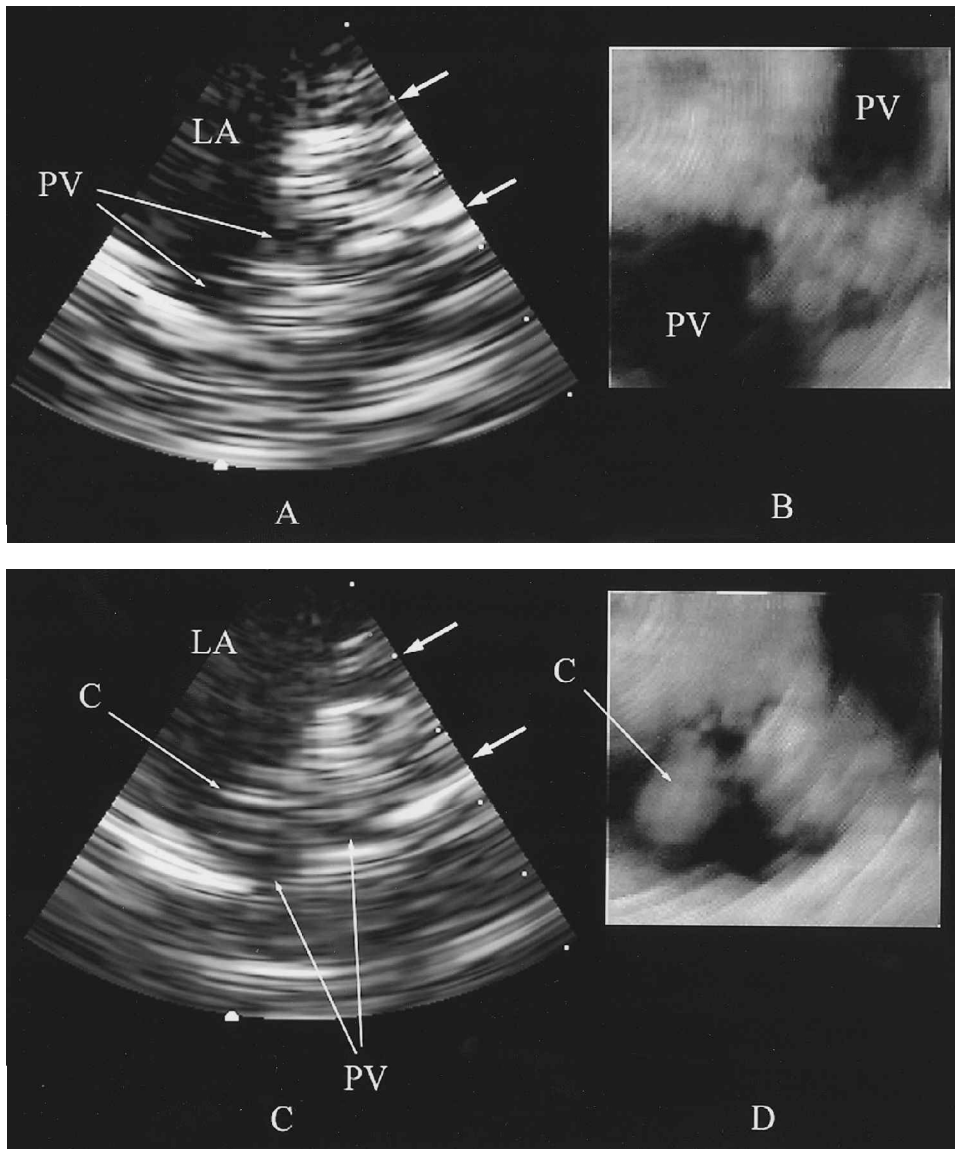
Three-dimensional intracardiac echocardiographic scan with imaging catheter in the left atrium (LA) including (A) a sector image of right pulmonary veins (PVs), (B) simultaneous real-time three-dimensional rendered image of en face view of the PVs, (C) sector image of PVs with mapping catheter in the lower vein, and (D) simultaneous three dimensional image with the mapping catheter in the lower vein.
